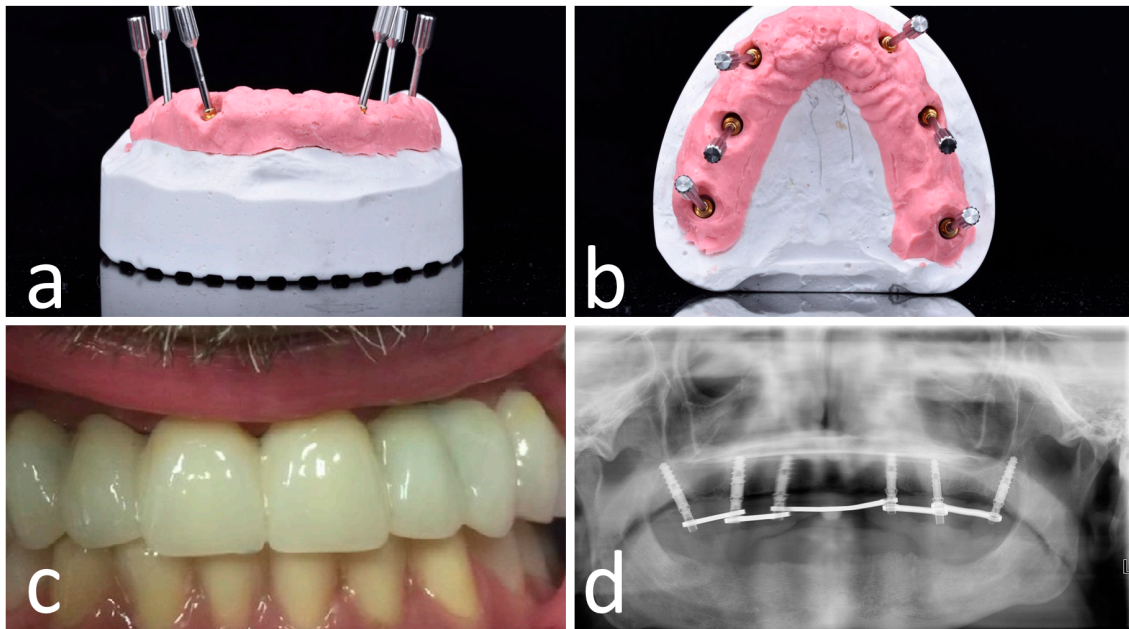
OT-bridge abutments use the “Extragate™” feature, a system allowing to compensate up to 80° of the divergence between two implants (a,b). Pictures c and d show the clinical (c) and X-ray (d) view of the provisional prosthesis using OT-bridge abutments.
